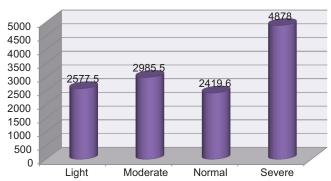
Mean value of serum ferritin based on MRI T2 grading
